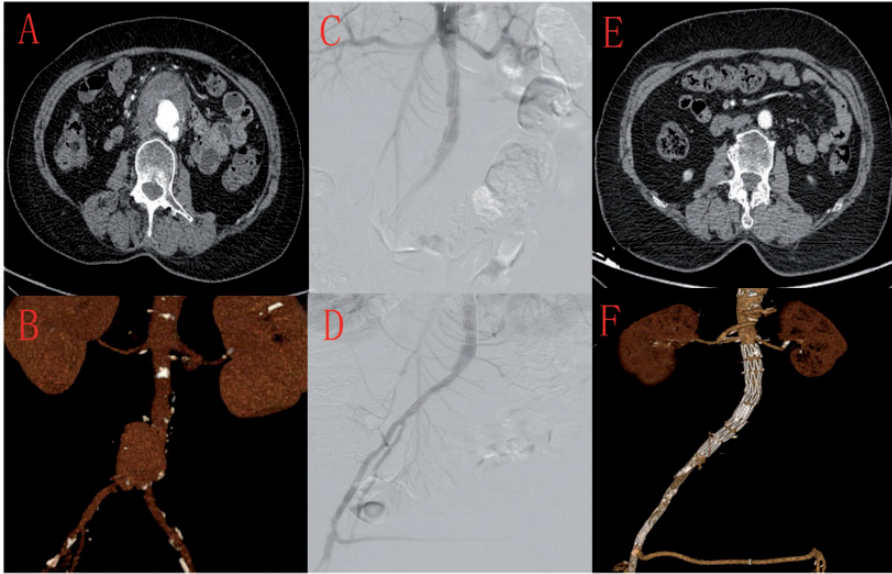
Imaging findings. (a, b) Preoperative computed tomography angiography showing a saccular aortic pseudoaneurysm at the abdominal aorta. (c, d) Aortogram demonstrating satisfactory endoluminal occlusion of the pseudoaneurysm after aorto-uni-iliac endovascular aneurysm repair with femorofemoral bypass. (e, f) Sixty-four-month postoperative computed tomography angiography showing complete eradication of the infected saccular aortic pseudoaneurysm in the abdominal aorta and patency of the bilateral femoral arteries.
